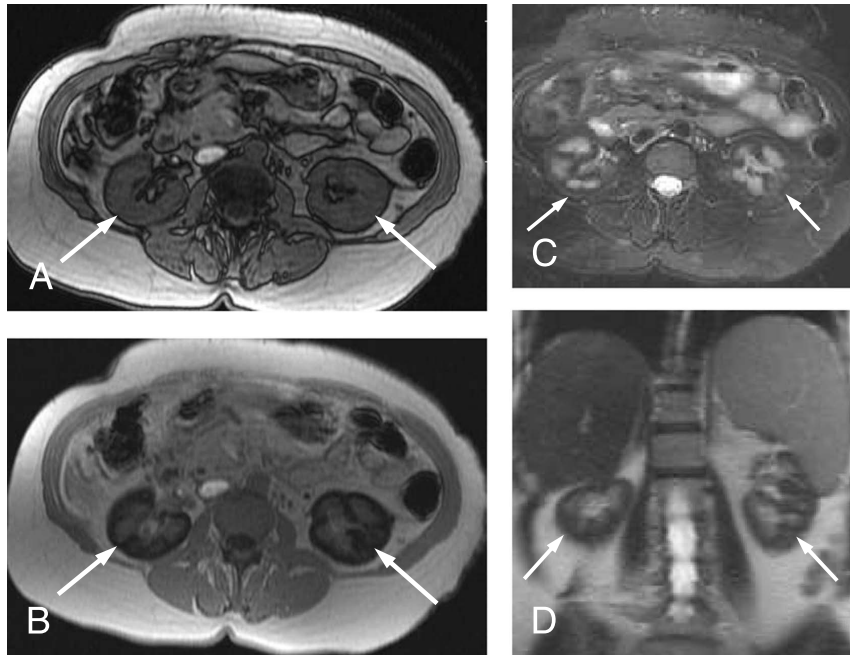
OP (TE, 2.2 milliseconds) (A) and IP (TE, 4.4 milliseconds) (B) GRE sequences in a patient with PNH show loss of signal in the renal cortex (arrows) on the longer TE IP sequence compared with the OP sequence. Note the reversal of the normal renal cortex-medulla differentiation on the IP GRE sequence. On T2-weighted sequences (C, D), the renal cortex is diffusely hypointense.
